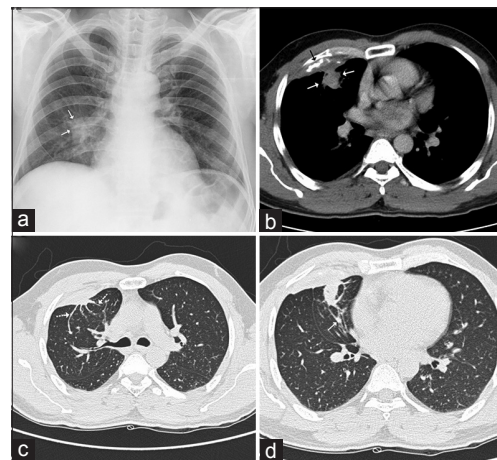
(a) Radiograph of the chest reveals an ill-defined opacity (arrows) in the right middle lobe. (b) Contrast-enhanced CT reveals pleural thickening with calcification (black arrow) with a subpleural nodular mass (arrows) with irregular margins. (c) Lung window shows bands entering the mass from all directions (dashed arrows) giving a “Crow’s feet” appearance. (d) Lung window shows bronchovascular bundles (arrow) converging towards the lesion giving a “comet tail appearance”
